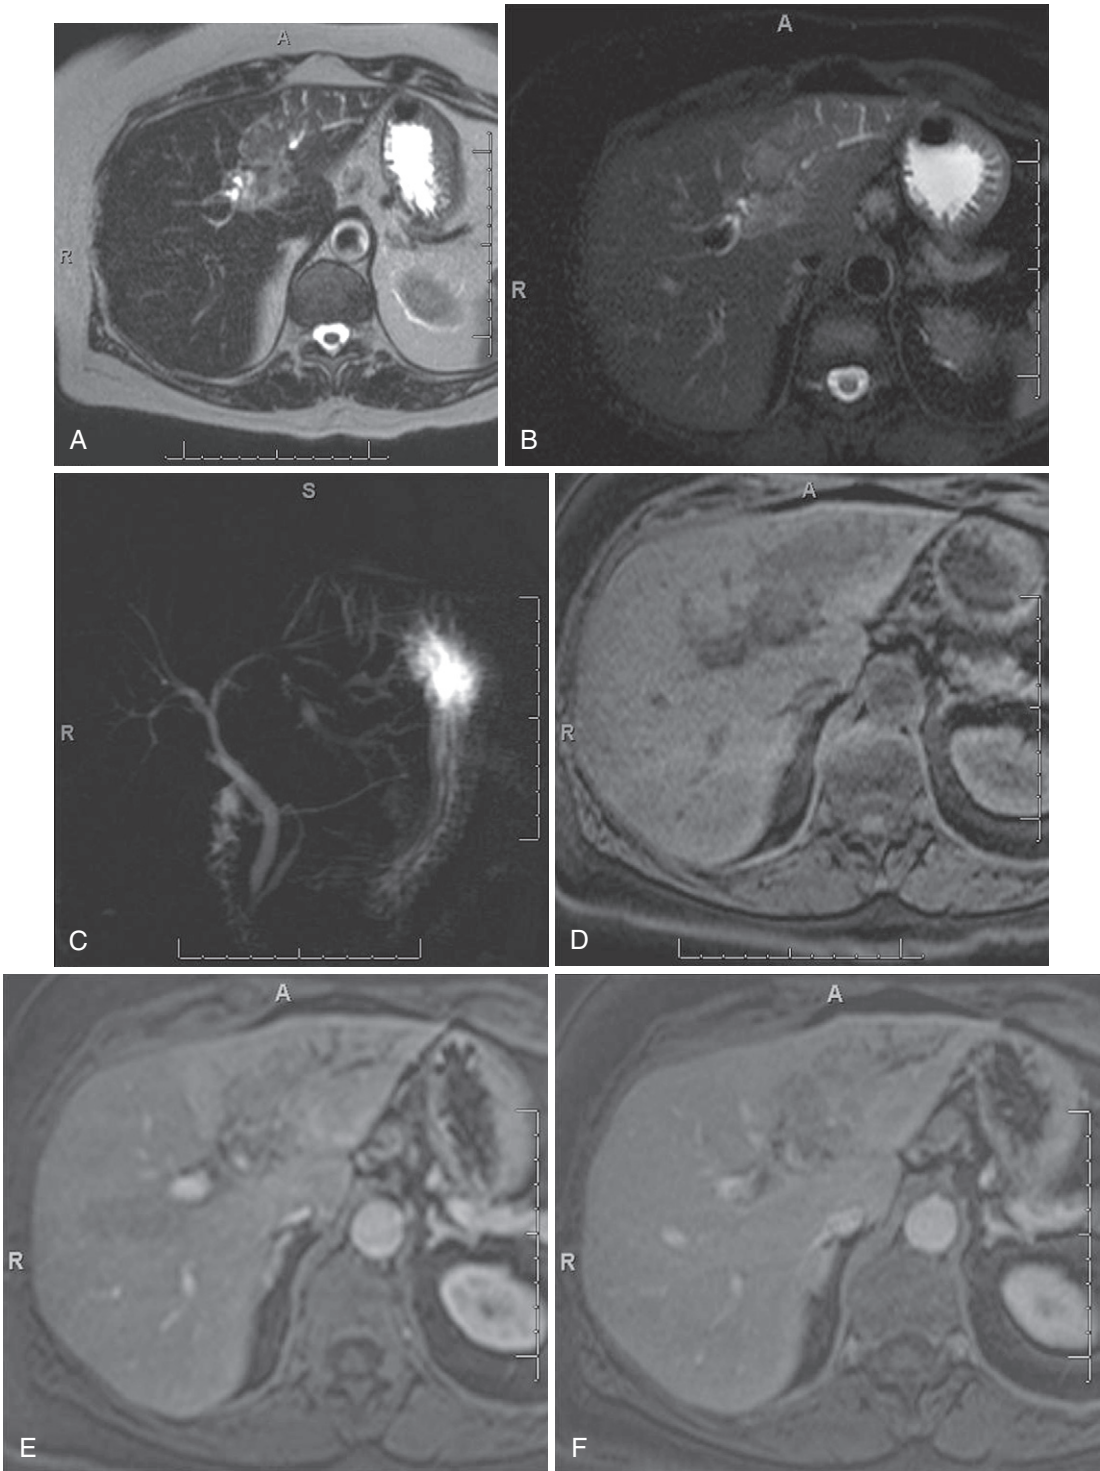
Hilar cholangiocarcinoma. T2-weighted (A), fat-suppressed T2-weighted (B), coronal thick-slab MIP MRCP (C), and precontrast (D), early arterial phase (E), and delayed phase (F) fat-suppressed T1-weighted gradient recalled-echo images demonstrate a mildly T2 hyperintense, gradually enhancing, intrahepatic, infiltrative mass with peripheral biliary radical dilatation.
